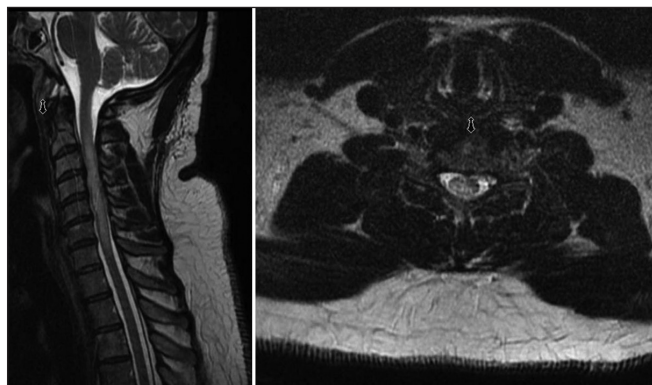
Sagittal (left) and axial (right) T2-weighted magnetic resonance imaging (MRI) demonstrating intramedullary hyperintensity without any enlargement of the spinal cord extending from the C3 to C6 level with superimposed cervical stenosis secondary to degenerative changes
